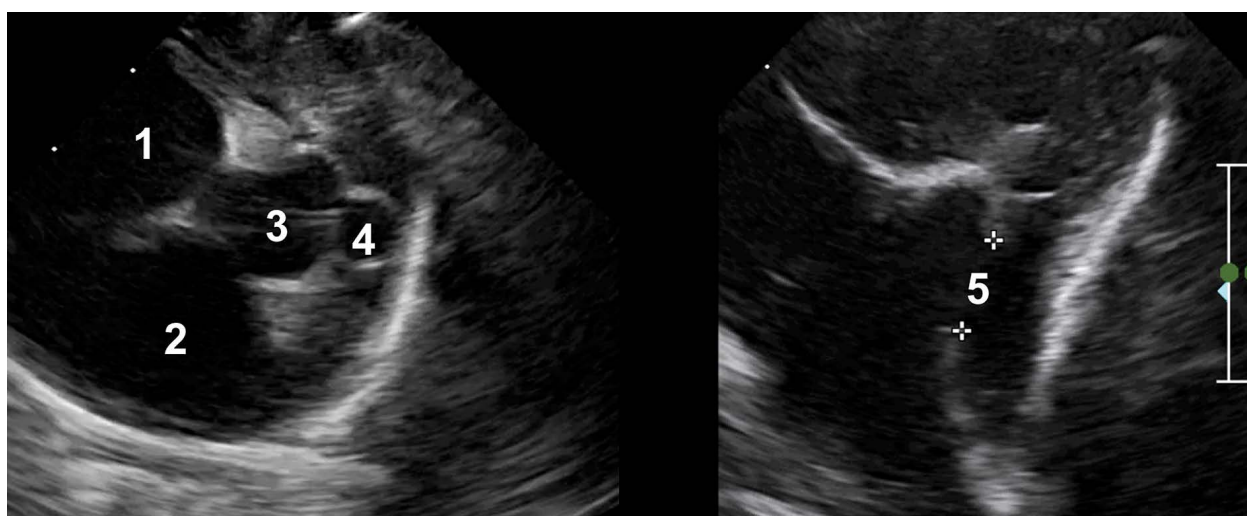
Postnatal echocardiography: the left image – a short axis view (vascular) with a confirmed presence of 2 annuli of the semilunar valves. Right image: the right ventricular outflow tract
